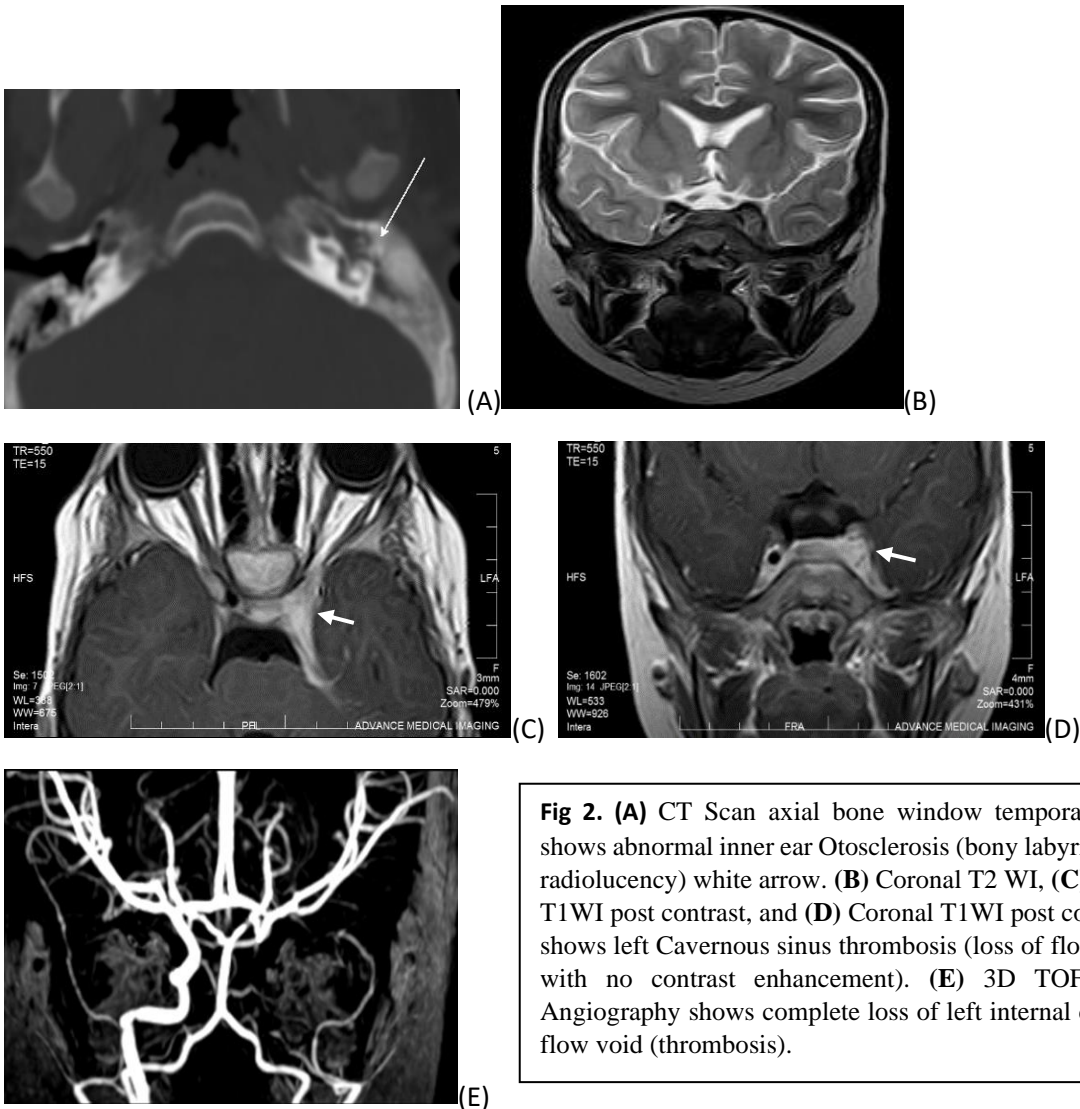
(A) CT Scan axial bone window temporal bone shows abnormal inner ear Otosclerosis (bony labyrinthine radiolucency) white arrow. (B) Coronal T2 WI, (C) Axial T1WI post contrast, and (D) Coronal T1WI post contrast: shows left Cavernous sinus thrombosis (loss of flow void with no contrast enhancement). (E) 3D TOF MRI Angiography shows complete loss of left internal carotid flow void (thrombosis).
